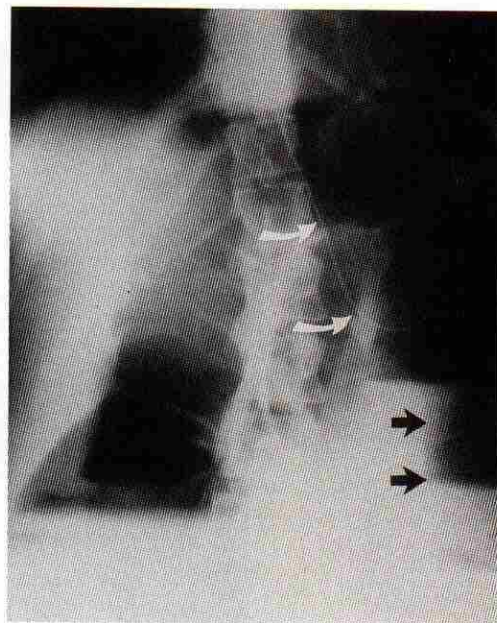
Plain upright abdominal radiograph of a 65-year-old man with a five-day history of constipation shows marked colonic dilatation and air-fluid levels to the sigmoid colon (black arrows). A nasogastric tube is present in the stomach (curved arrows).
